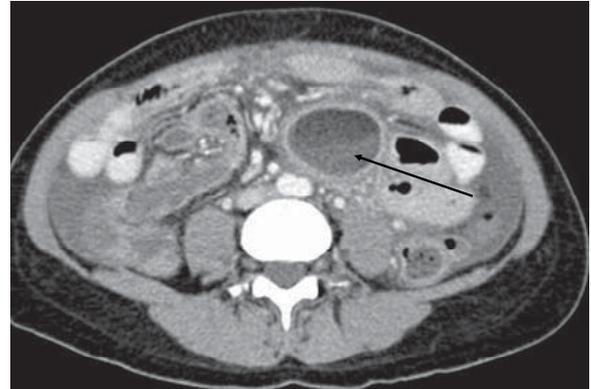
Computed tomographic (CT) scan showing the cystic lesion in the mesentery of the small bowel (arrow).
